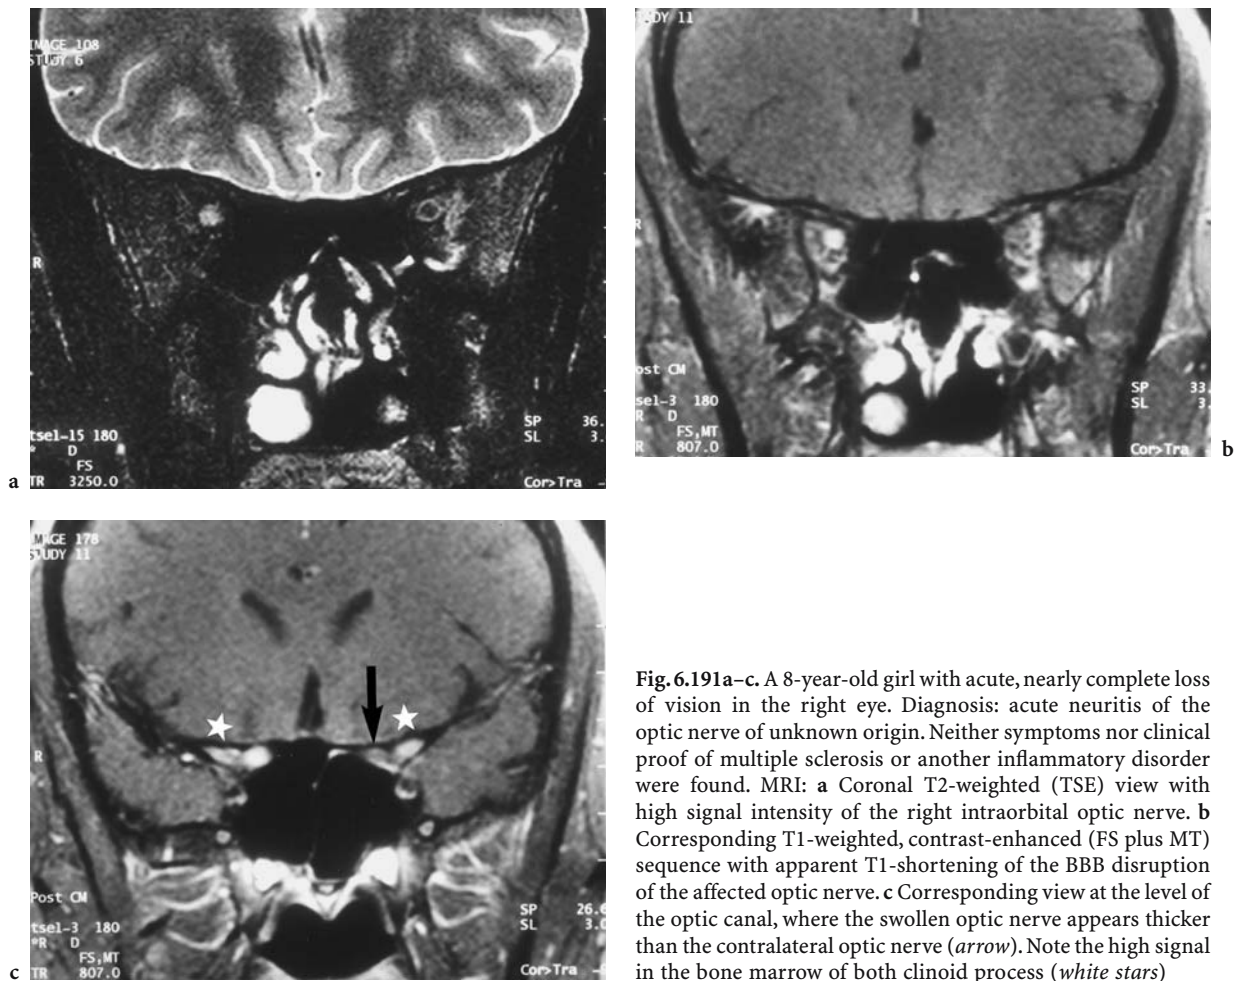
A 8-year-old girl with acute, nearly complete loss of vision in the right eye. Diagnosis: acute neuritis of the optic nerve of unknown origin. Neither symptoms nor clinical proof of multiple sclerosis or another inflammatory disorder were found. MRI: a Coronal T2-weighted (TSE) view with high signal intensity of the right intraorbital optic nerve. b Corresponding T1-weighted, contrast-enhanced (FS plus MT) sequence with apparent T1-shortening of the BBB disruption of the affected optic nerve. c Corresponding view at the level of the optic canal, where the swollen optic nerve appears thicker than the contralateral optic nerve (*arrow*). Note the high signal in the bone marrow of both clinoid process (*white stars*)
